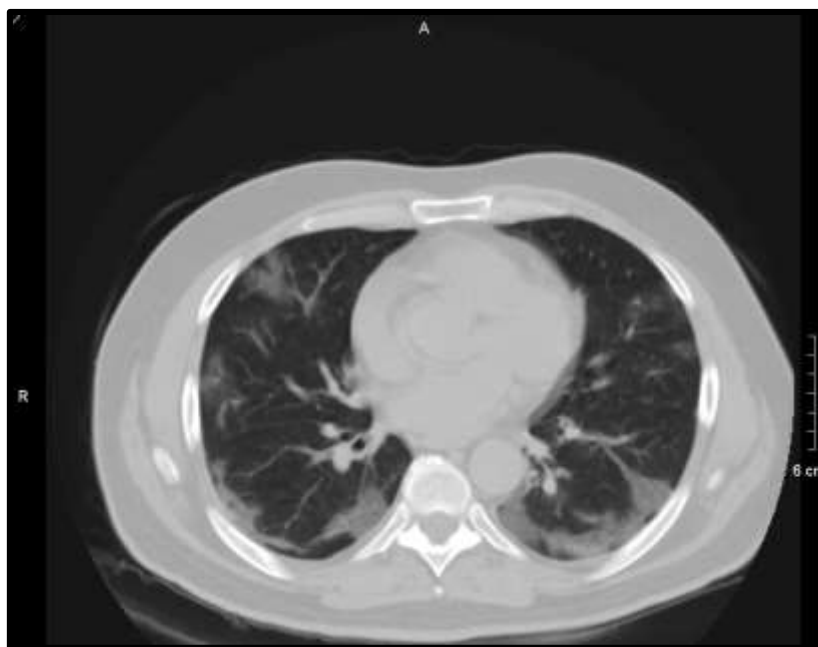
CT chest of a case showing areas of ground glass opacities distributed peripherally in both lung fields
